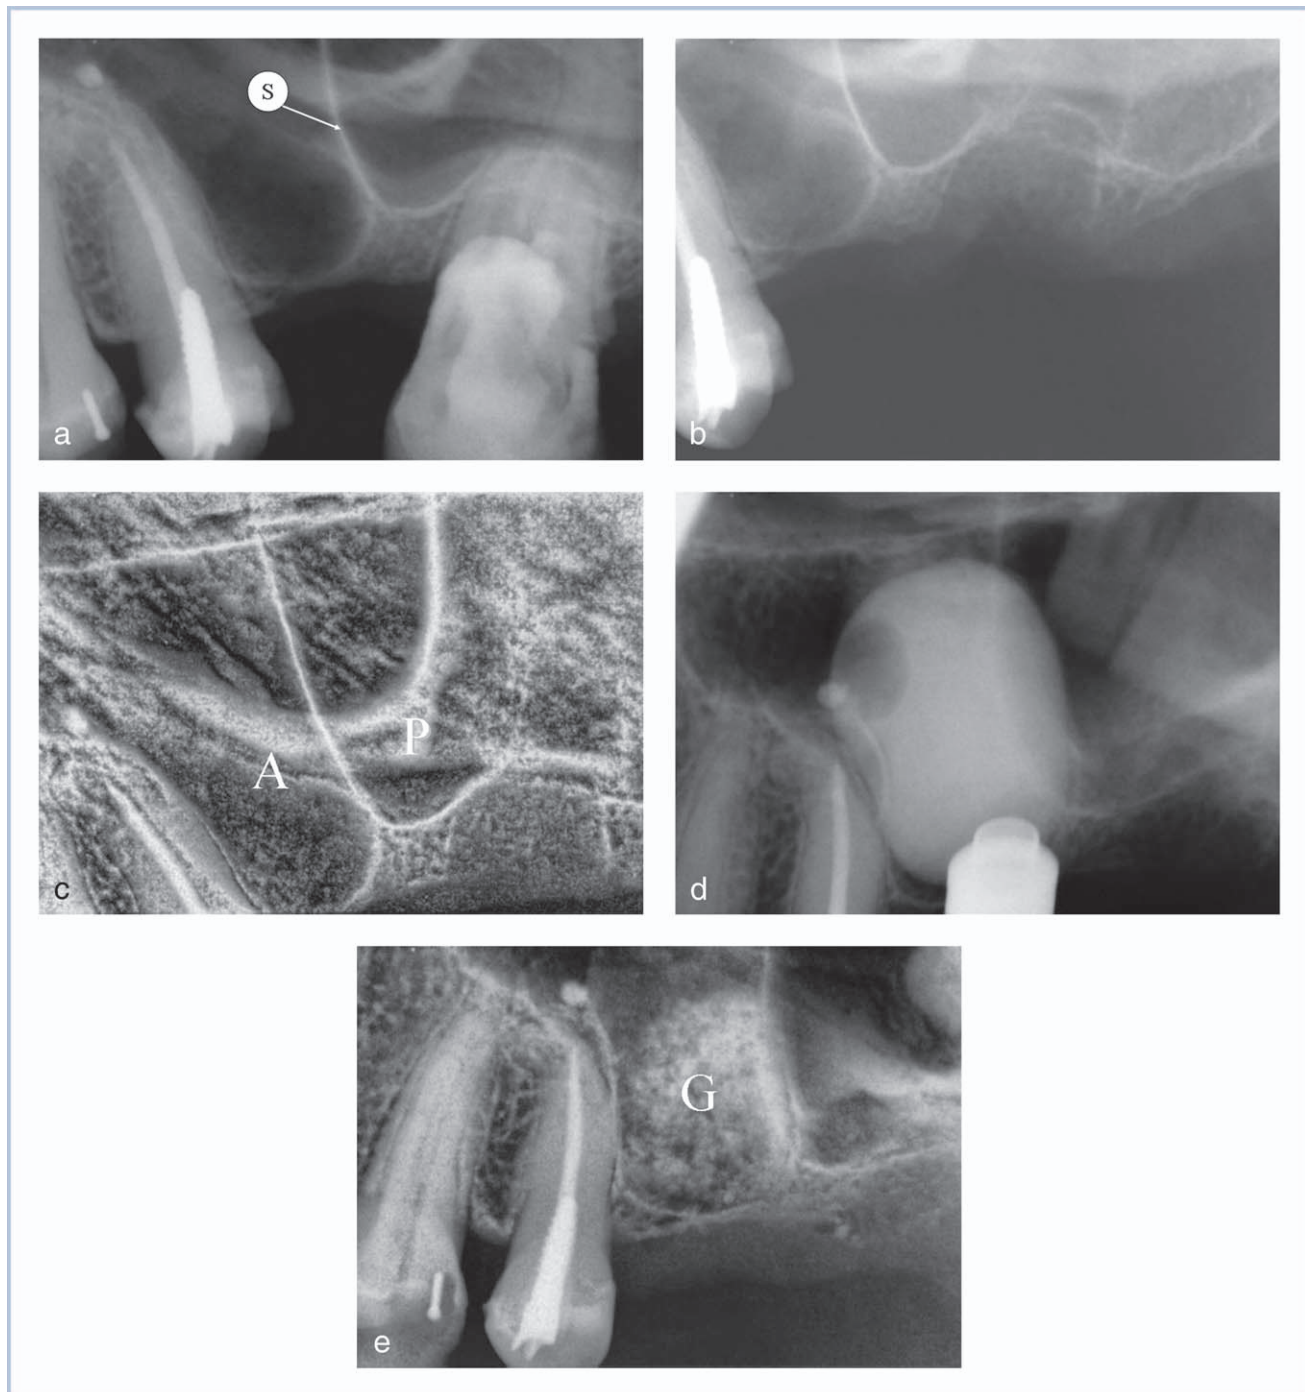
Case 1. (a) Pre-extraction radiograph area 26–27, bone height is approximately 1 mm with a developed septum (S). (b) Post extraction in area 27—there is no floor in—only the sinus membrane. (c) Anterior (A) and posterior (P) compartments. (d) MIAMBE first balloon inflation. (e) Bone grafting (G) in the anterior compartment.
